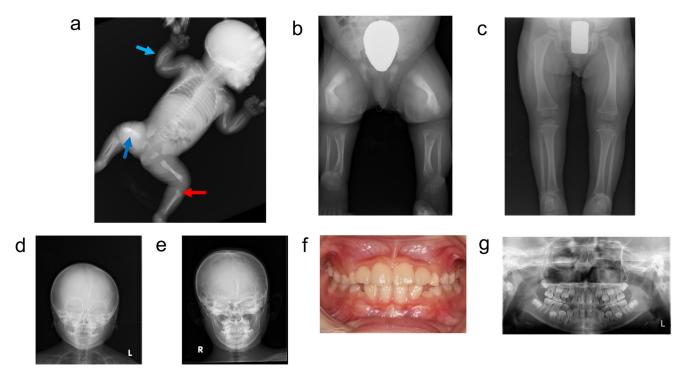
Bone radiographs and intraoral photographs of Patient 1. (a) At birth, the patient exhibited hypomineralization, irregular and widened metaphyses (red arrows), and bowing of long bones (blue arrows) but had no thoracic hypoplasia or cranial abnormalities. (b) At 27 d, the bowing and hypomineralization of the long bones worsened. (c) Lower limbs at 1 yr and 10 mo. (d) Head radiograph at 1 yr and 10 mo. Premature fusion in the sagittal and frontal sutures are obserbed. (e) At 9 yr and 11 mo. Craniosynostosis did not improve with continued asfotase alfa (AA) treatment. (f) Intraoral photographs of Patient 1 at 8 yr and 9 mo. The patient had no loose teeth. No problems with permanent tooth eruption were encountered. (g) Panoramic radiograph of Patient 1 at 8 yr and 9 mo. No major abnormalities.
